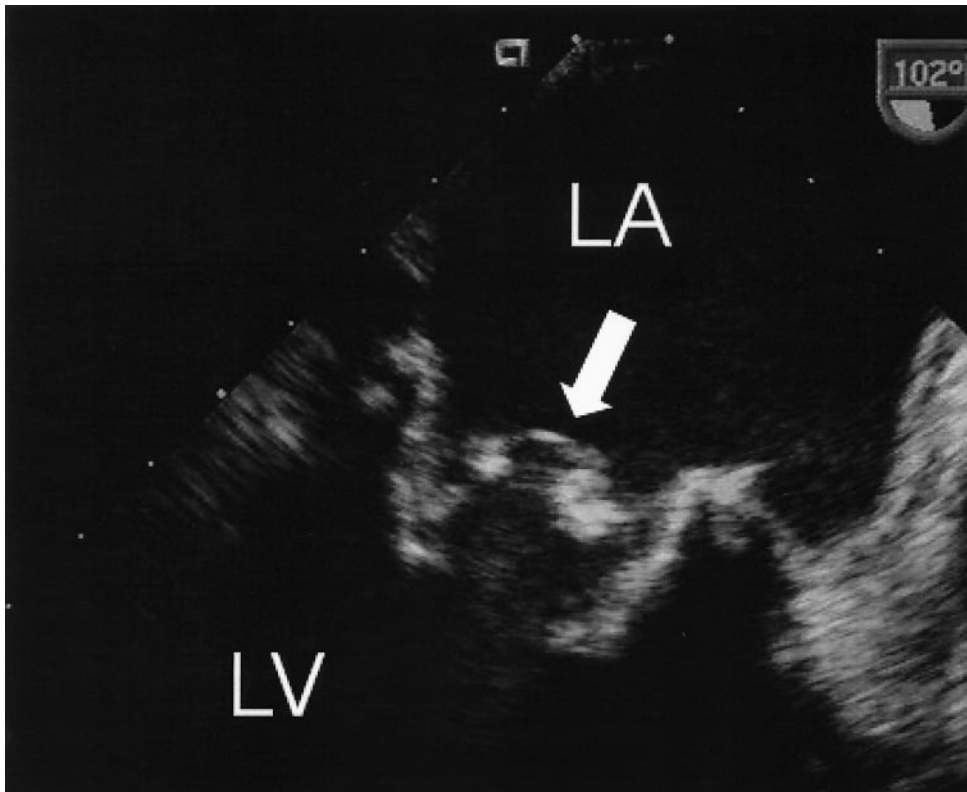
Transesophageal echocardiogram of infected mitral bioprosthesis. The leaflets of the mitral bioprosthesis (arrow) are thickened and studded with globular echo densities consistent with vegetations. On color Doppler (not shown), there was severe transvalvular mitral regurgitation. LA, left atrium; LV, left ventricle.
